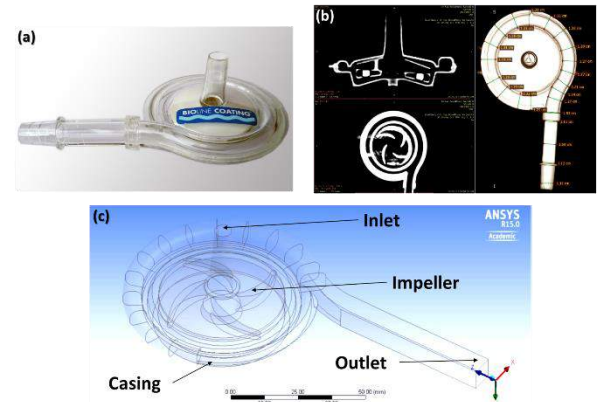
(a) The Maquet Rotaflow centrifugal blood pump (b) CT scan of pump head (c) Digitally reconstructed CAD model
